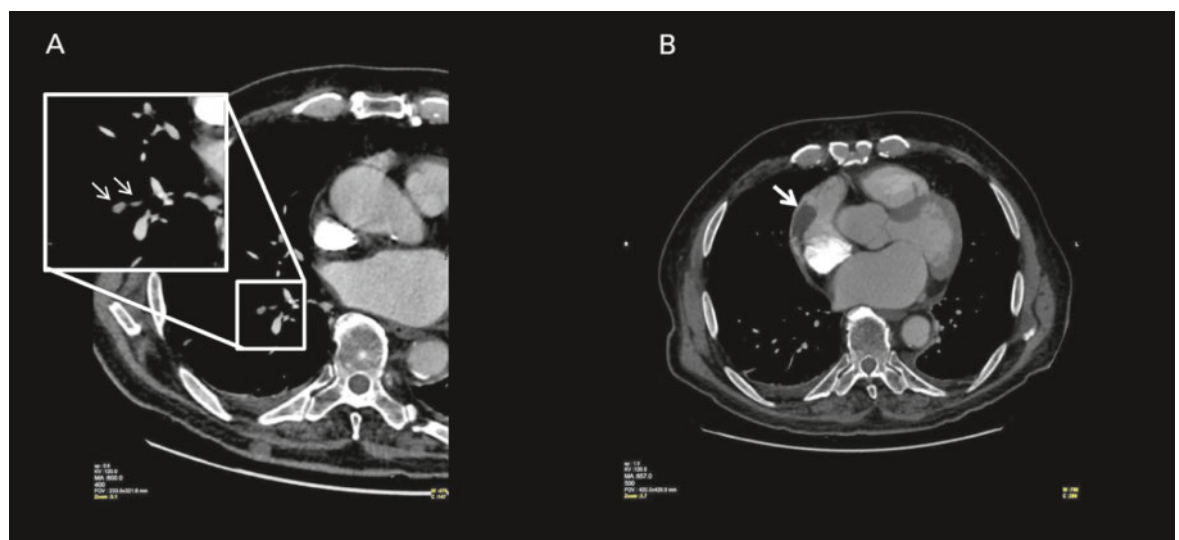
Thoracic computed tomography with contrast; (A) white arrow point to right segmental pulmonary embolus; (B) white arrow points at thrombus in the right atrium.
